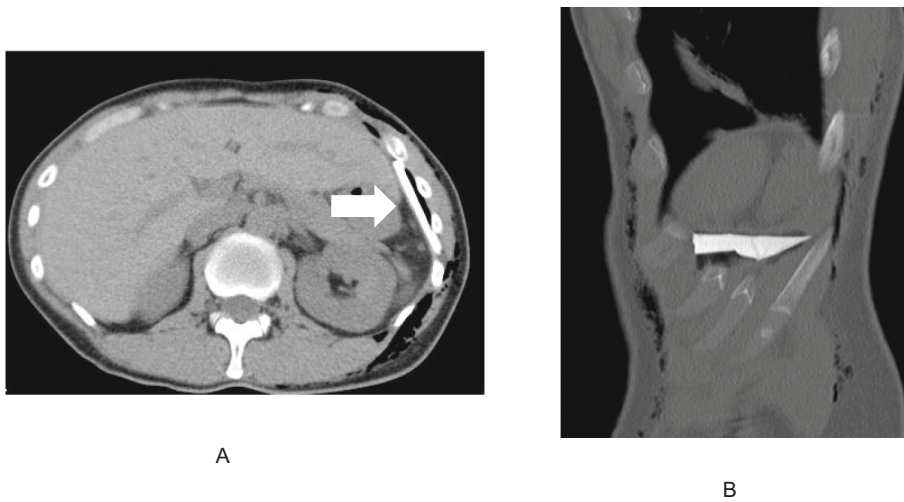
A: Chest computed tomography. A rod-shaped foreign body was observed on the left diaphragm angle.
